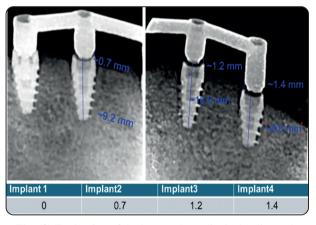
Evaluation of the bar gap by periapical radiograph
